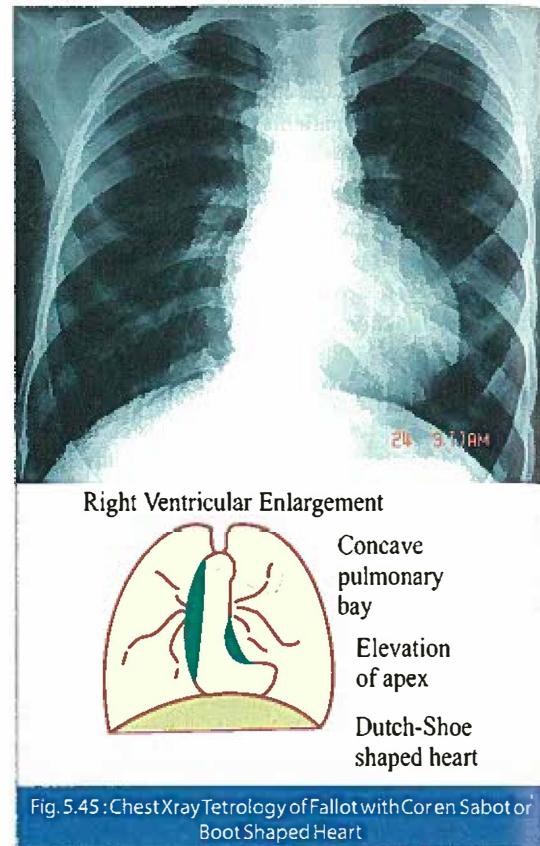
Chest X-ray Tetralogy of Fallot with Coeur en Sabot or Boot Shaped Heart
